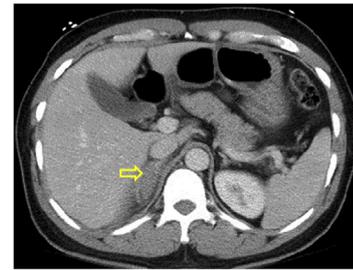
Axial contrast enhanced CT scan of the abdomen showing an ovoid mass 2.1 × 2.4 cm replacing the right adrenal gland (arrow). The mass is hyperdense with a density of 60 HU consistent with a hematoma.
